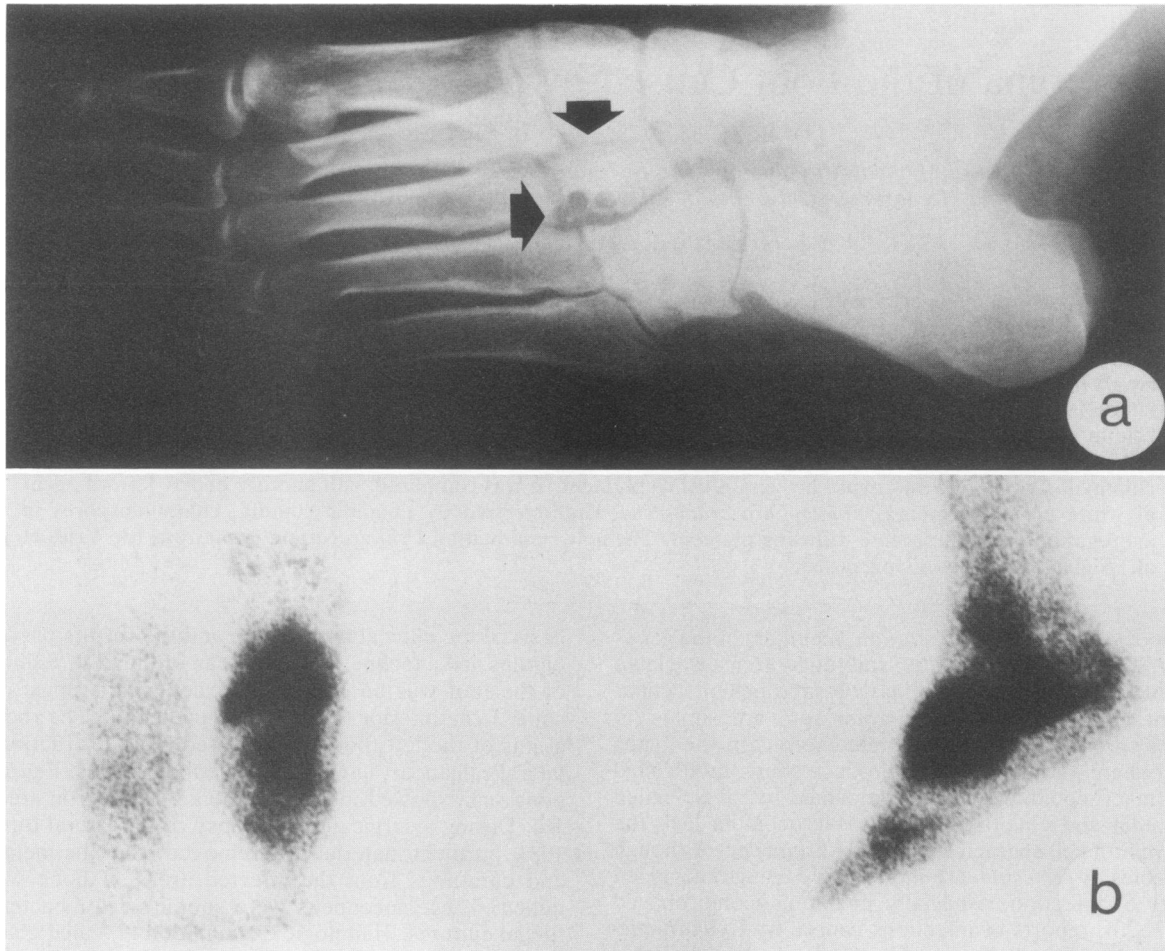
(a) Roentgenogram of the left foot demonstrating lytic bone destruction of the tarsals and the base of the third metatarsal (arrows). (b) Technetium-99m bone scan of the left foot taken 3 h after injection of technetium-99m demonstrating uptake of the technetium throughout the foot. The scan in panel b was taken at the same time as the roentgenogram shown in panel a (1984).
